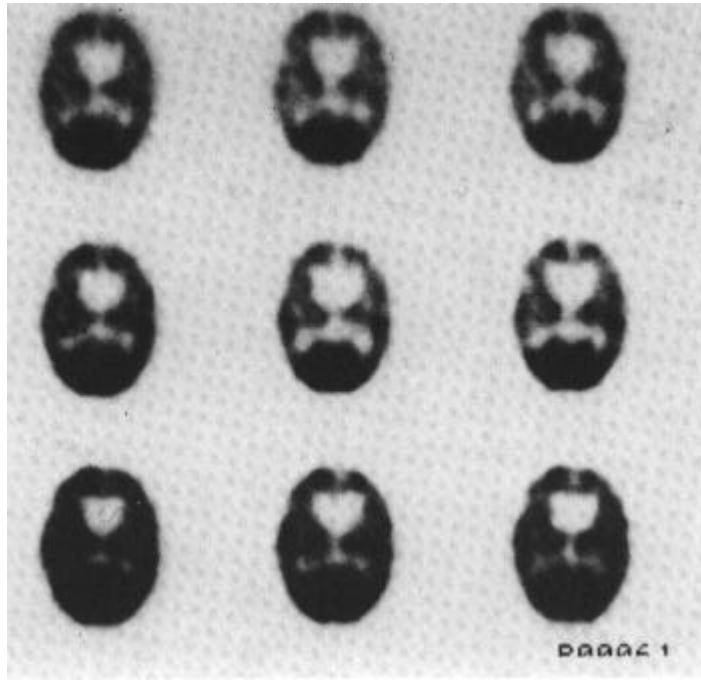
(a) Sequential images of ^{18}F FDG distribution in vascular dementia
